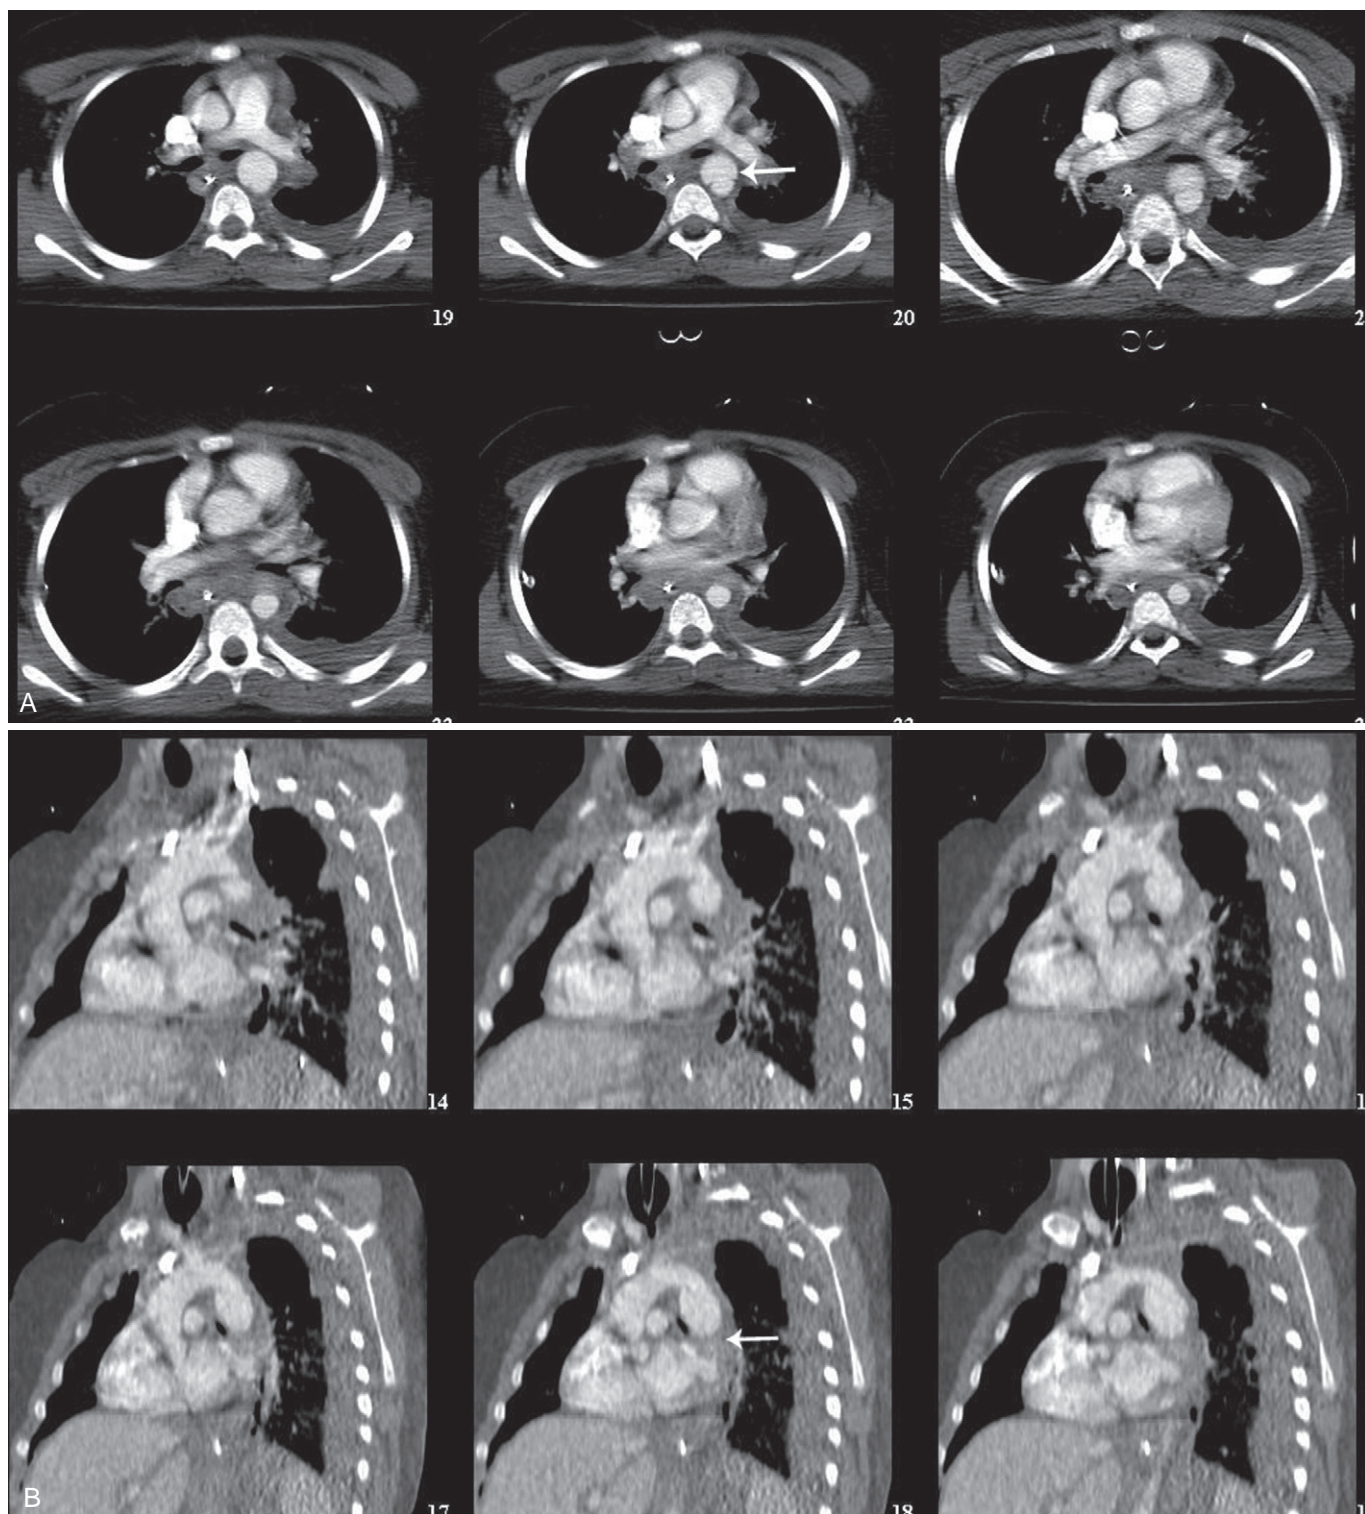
Helical computed tomography (CT) scan reconstruction showing traumatic rupture of the aorta in a 14-year-old boy. A, Transaxial view. Note periaortic hematoma at the isthmus. B, Three-dimensional reconstruction. Note interruption of flow at the isthmus.
